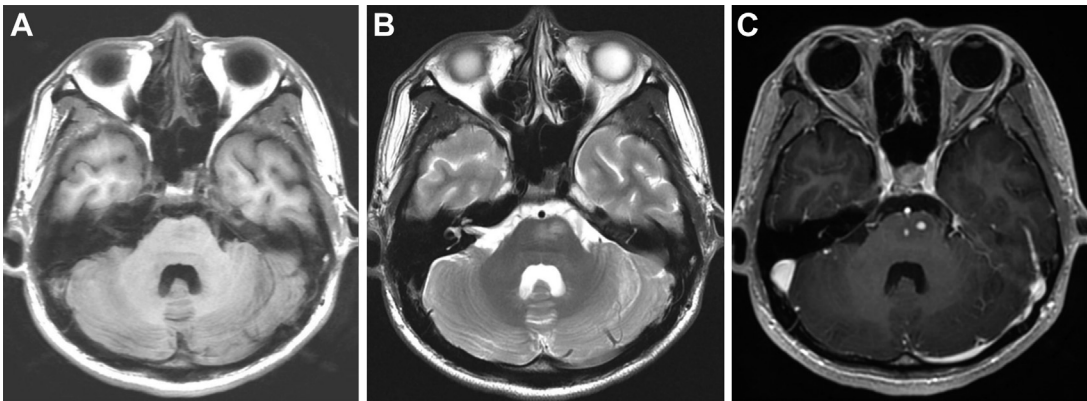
Noncaseating tuberculoma. Axial T1-weighted MR imaging (A) shows a hypointense lesion in the ventral pons. Corresponding axial T2-weighted MR imaging (B) shows infiltrative high signal intensity, with homogeneous contrast enhancement on axial T1-weighted postcontrast MR imaging (C).
